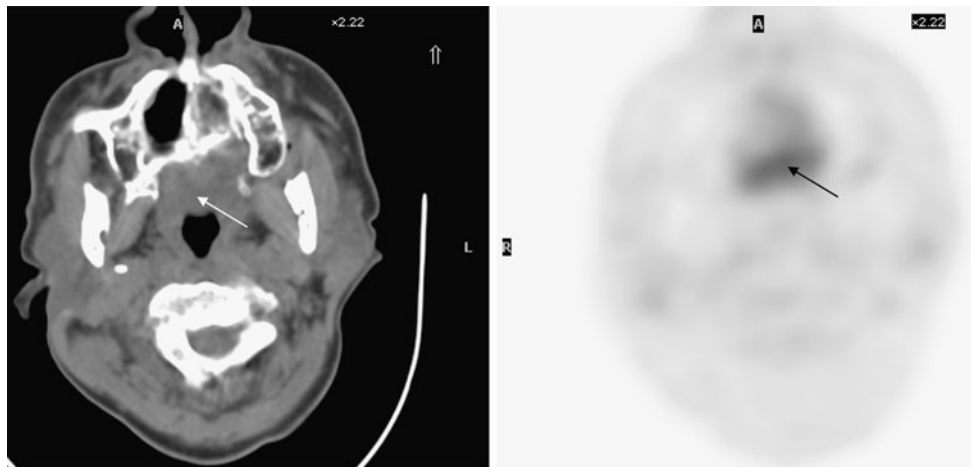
Soft palate KS in a 57-year-old man with AIDS. Transaxial images of FDG PET-CT show intense uptake (SUV 8.0) in the soft palate (*arrows*). KS lesion in the month is usually macular rather than a well-margined discrete mass
